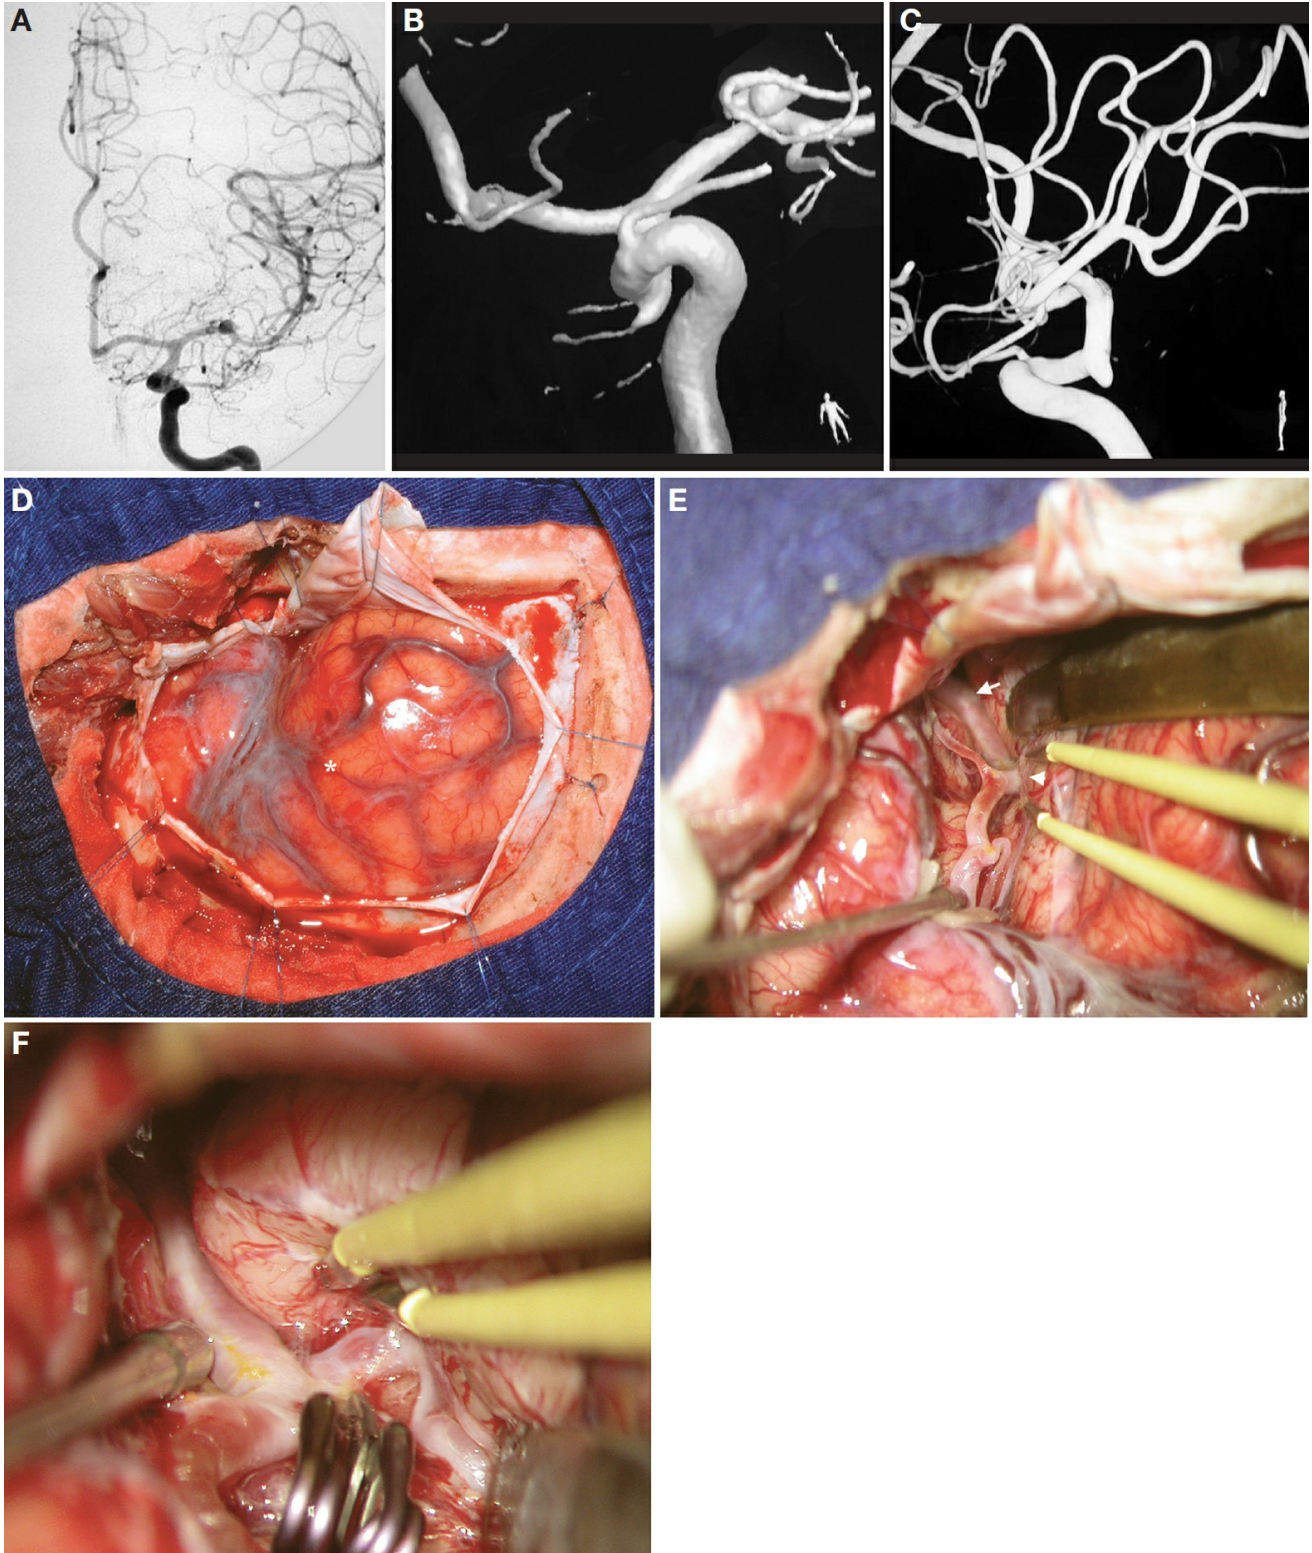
A, AP view of a left carotid angiography depicting an MCA aneurysm arising approximately midway between the carotid bifurcation and the genu of the MCA. B, angiography-computed tomographic (CT)
